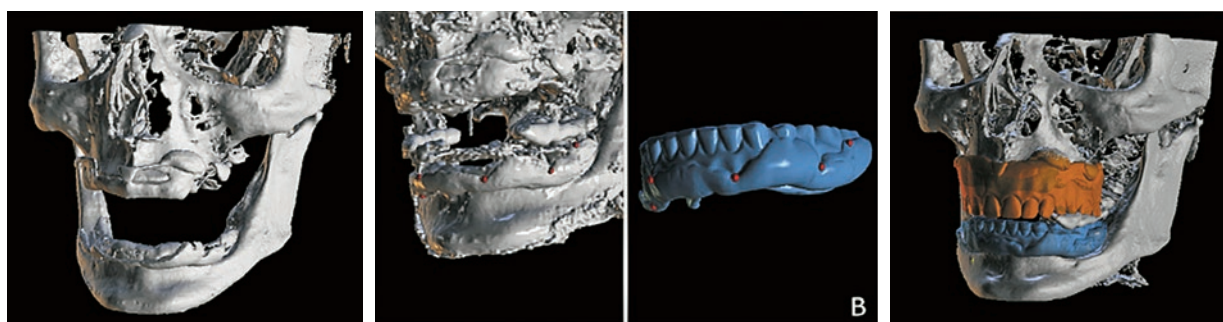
A 3D reconstruction of CBCT scans for the creation of a virtual patient
